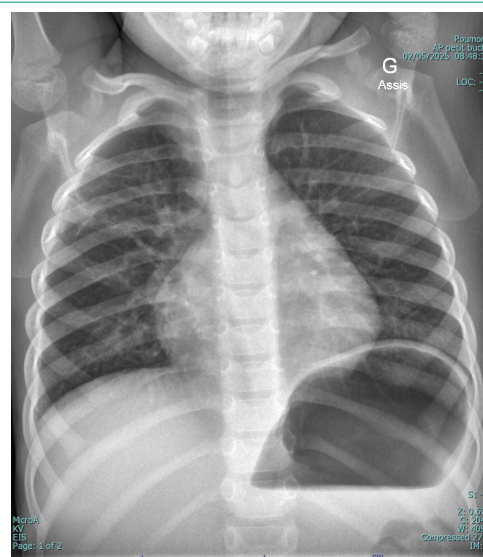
Chest radiograph at his most recent follow-up revealed complete resolution of his hydropneumothorax with only mild residual pleural thickening and fibrotic changes.
